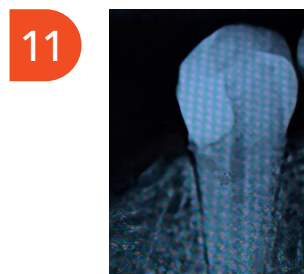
X-ray, sealing evaluation.
